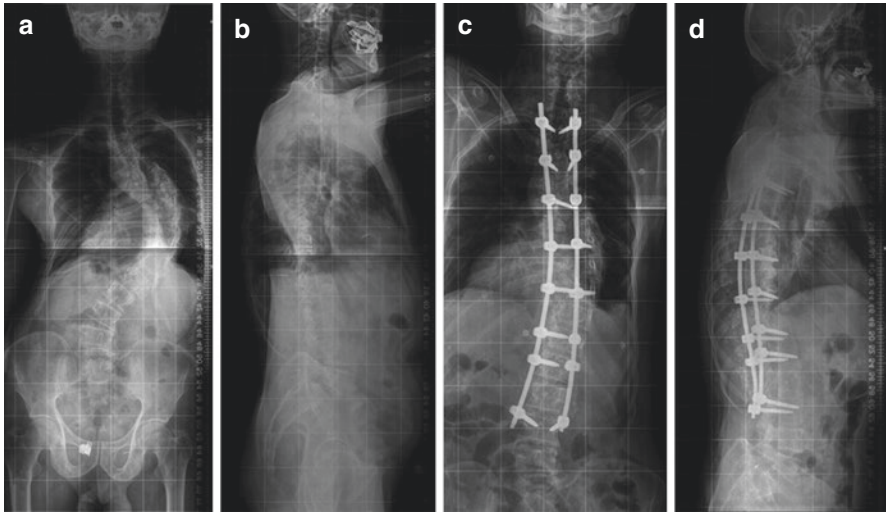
(a and b) Preoperative X-ray images of a patient with AdIS with the thoracic Cobb angles of 82° . (c and d) After surgical correction, the thoracic Cobb angle was decreased to 22°
